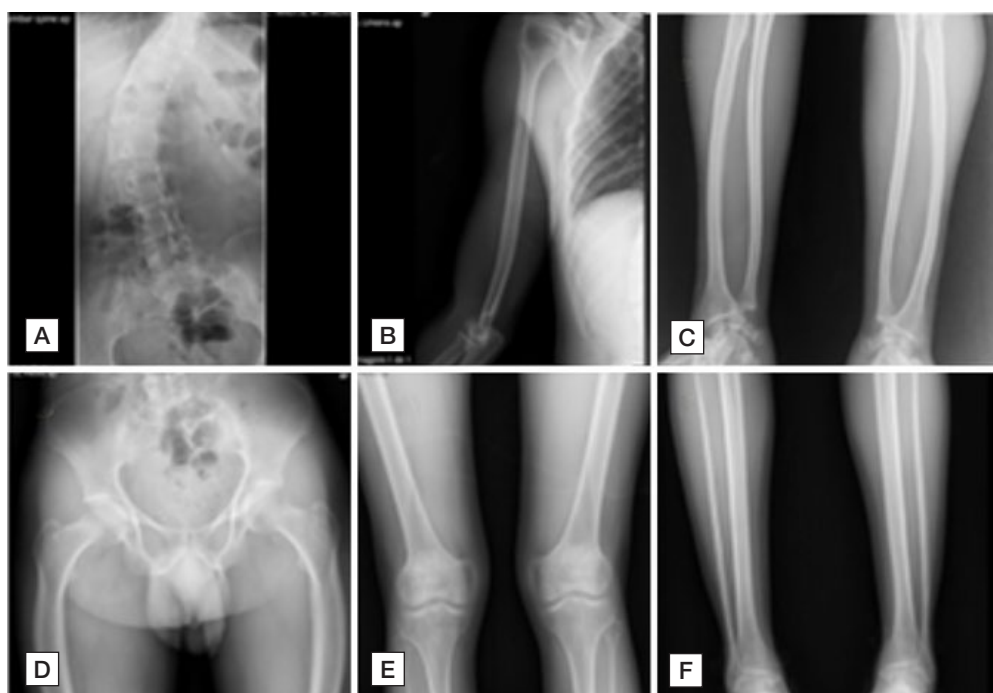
Skeletal radiograph of the older brother. Marked scoliosis [A]. Long bones appear radio-lucent with thin cortices. Severely thinned diaphyseal cortices (“pencil-thin”) can easily be seen in ulnerus [B], radius and ulna [C], femur [D,E] and tibia and fibula [F]. Femur lateral bowing [D].
